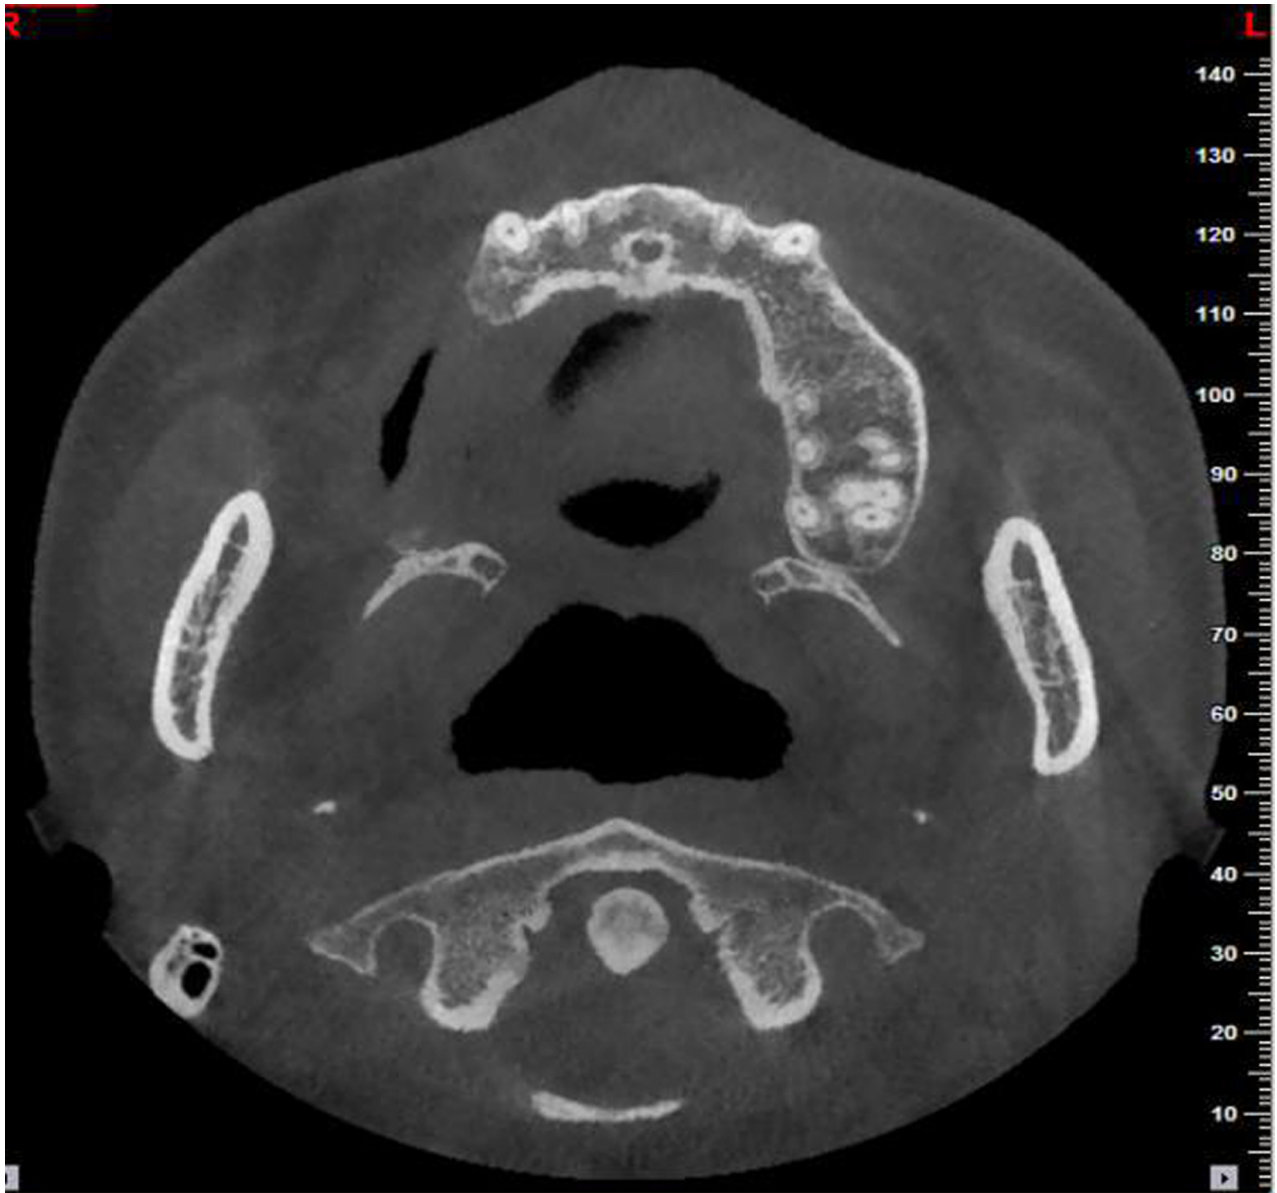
Preoperative axial computed tomograms showing severe ridge defects.
